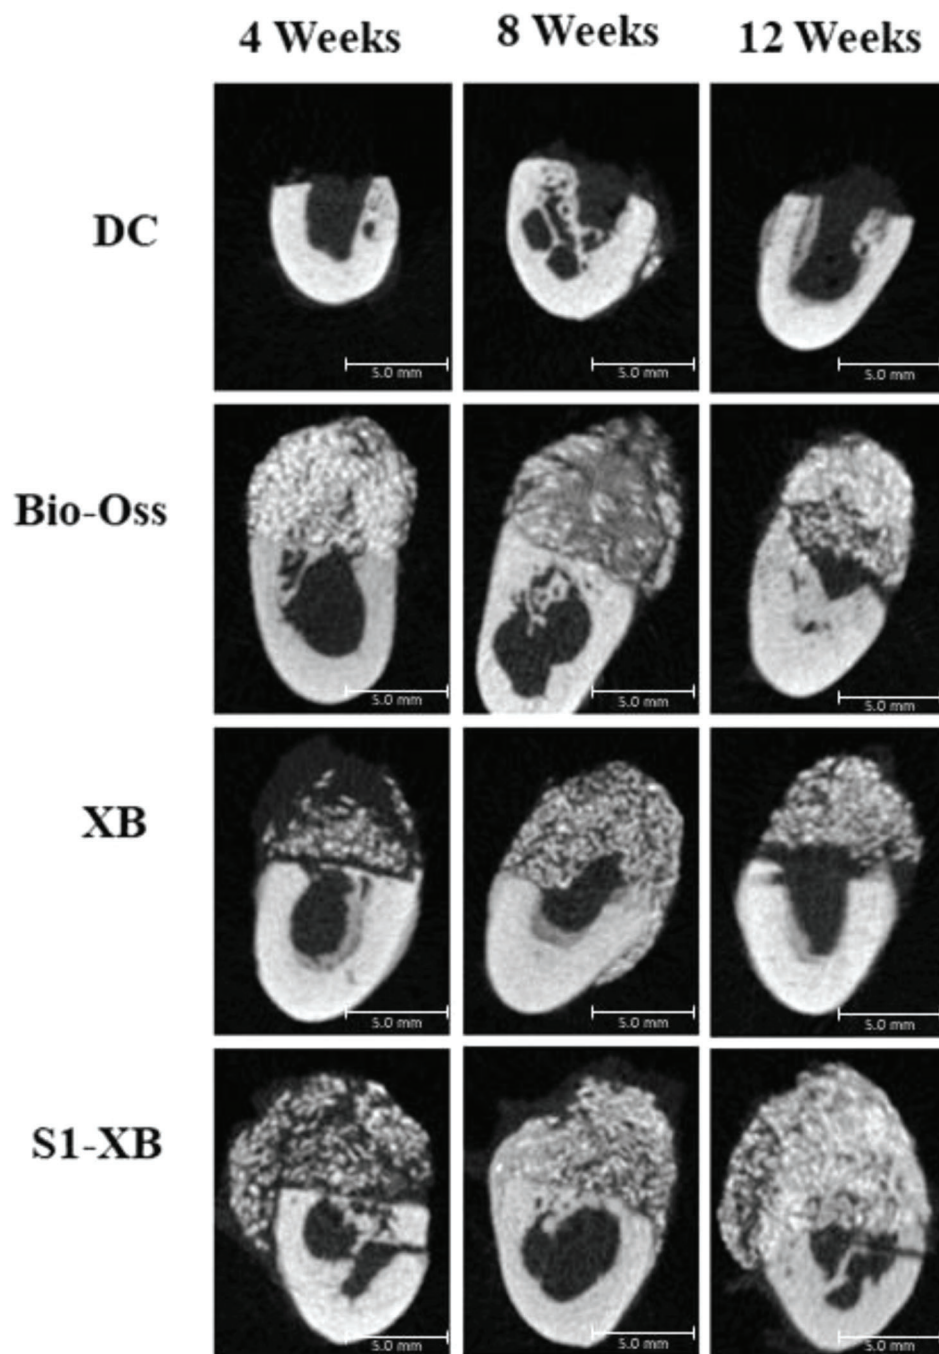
Representative micro-computed tomography showing bone formation after 4, 8, and 12 weeks healing.
